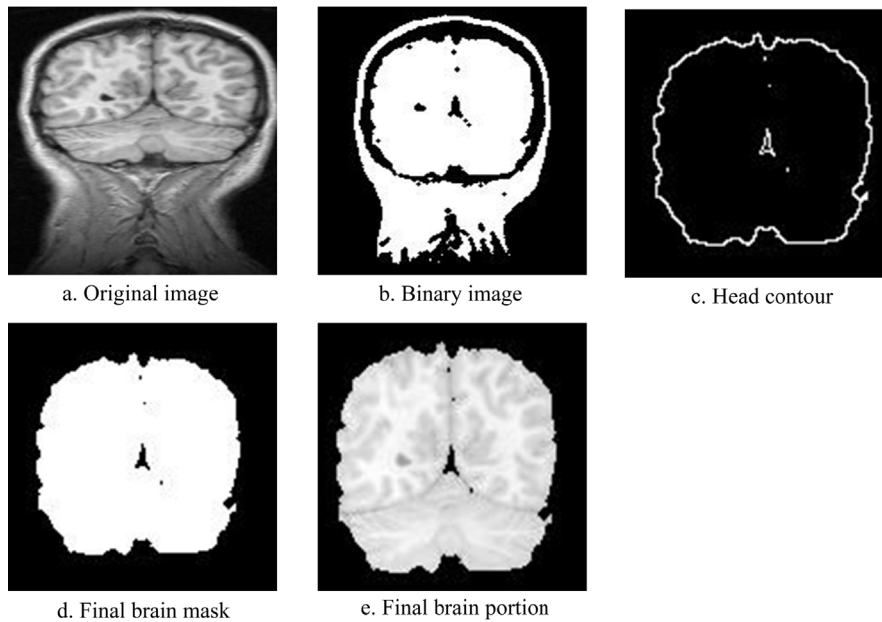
Brain only image extraction process from MR image.
